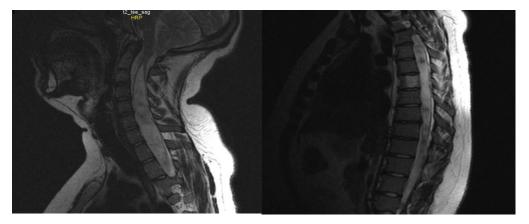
Sagittal T2-weighted MRI of spinal cord of 24-Year-Old Man with Chiari 1 Malformation and Syringomyelia: huge single syringomyelic cyst with a length from segment C2 to Th12. Upper flaccid paraparesis of muscle and atrophy in hands was developed with the absence of motor disorders in the lower extremities A peculiarity of this case is the absence of clinical manifestations characteristic of syringomyelia in the form of loss of pain and temperature sensitivity with preserved tactile and vibration sensitivity (segmentally dissociated loss of sensitivity).
